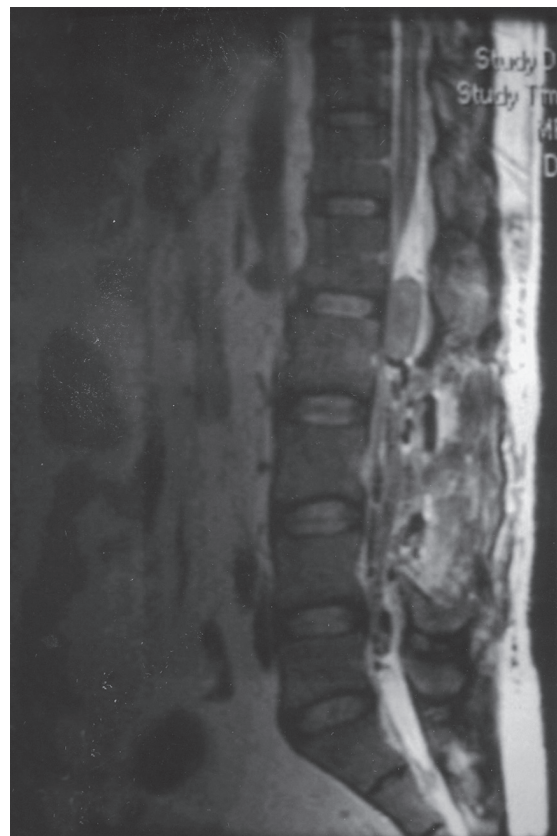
Intraoperative sagittal T2-weighted lumbosacral MR imaging shows tumour has moved cranially to L1/2 interspace.
